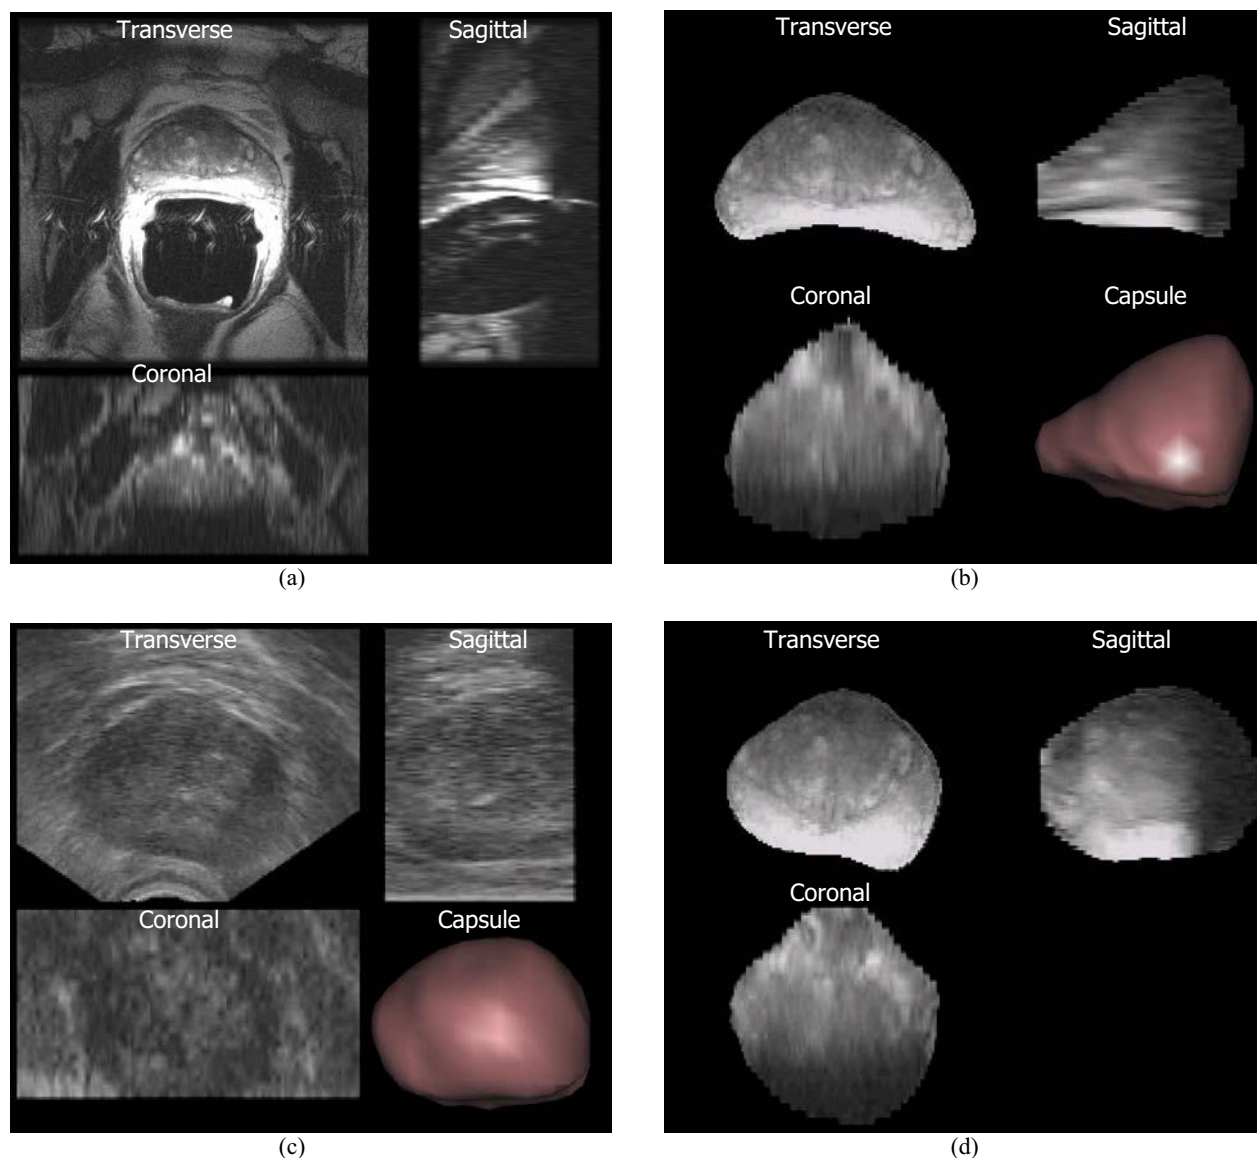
Registration experiment on patient data. (a) Original T2-weighted MRI images. (b) Segmented prostate from (a). (c) Original TRUS images and segmented prostate. (d) Registration result. Transformation was applied to (b), with the aim to match with (c).
